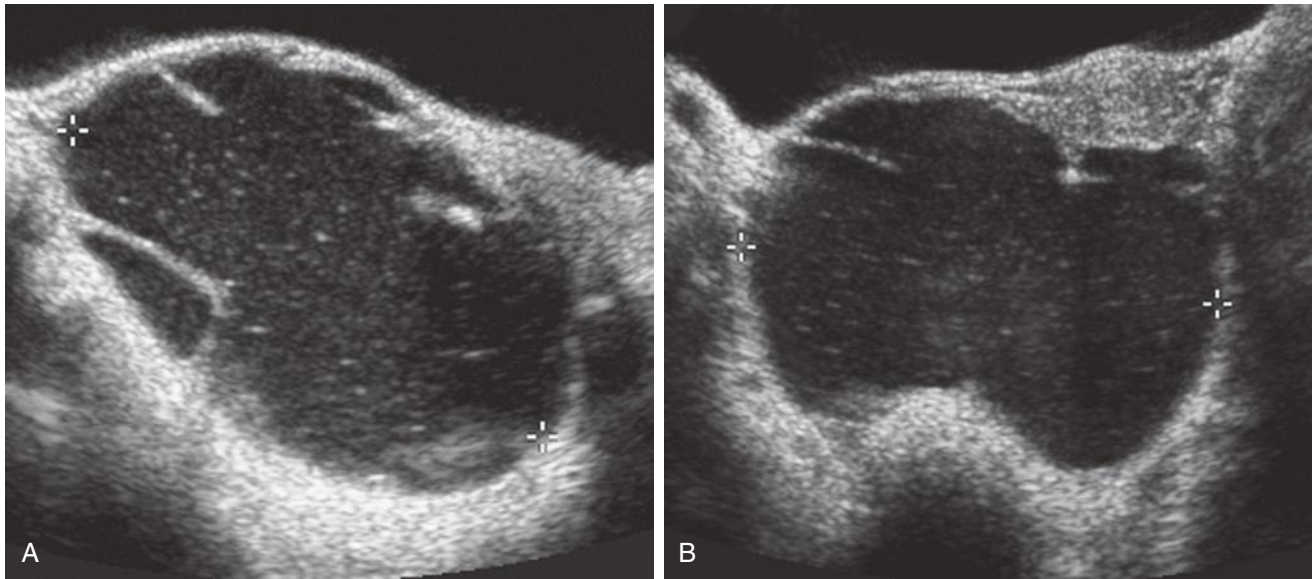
Mucinous cystadenoma in a 15-year-old girl with prolonged vaginal bleeding. Sagittal (A) and transverse (B) ultrasound images depict a large, cystic mass in the right adnexal region (between cursors). The mass contains multiple septations and echogenic debris.
